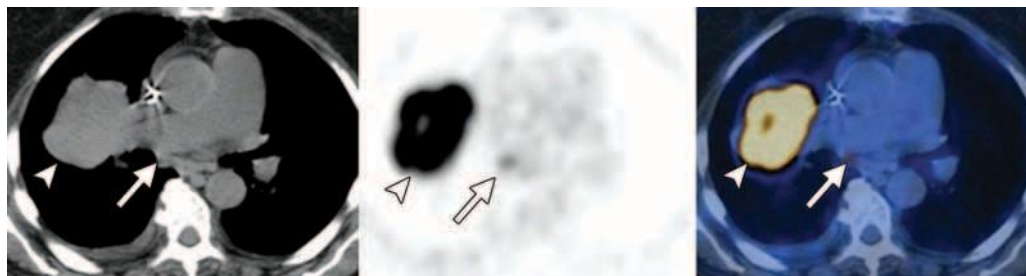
Distant organ metastases in an 89-year-old woman with elevated CA-125 levels and a history of surgery and chemotherapy for stage IIIC ovarian serous papillary adenocarcinoma. Axial contrast-enhanced CT (left), FDG PET (middle), and fused PET/CT (right) images show a large lobular mass (arrowhead) with a photopenic center in the right upper lobe that demonstrates markedly increased FDG uptake, a finding indicative of distant organ metastasis. A mildly hypermetabolic subcarinal lymph node (arrow) and a nonhypermetabolic small right pleural effusion are noted; however, these are nonspecific findings and may be either malignant or benign.
